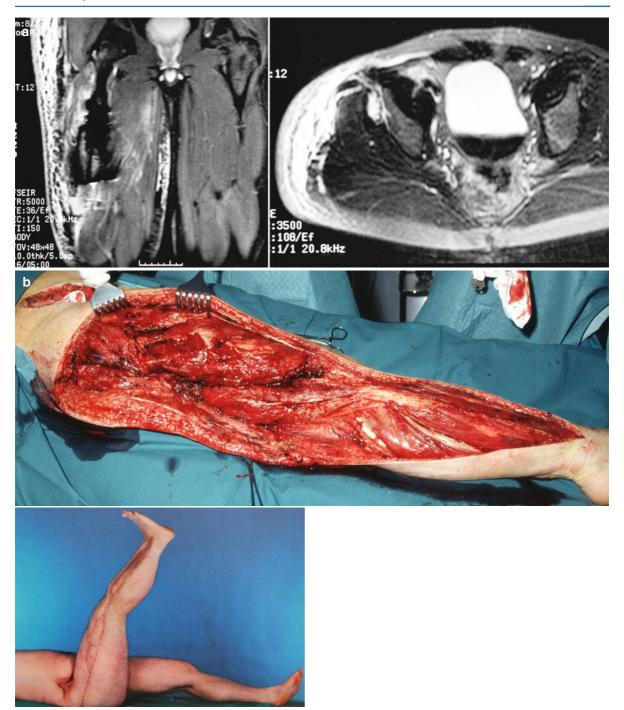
(a) Myonecrosis of right thigh because of *Clostridium perfingens*: MRI at admission. (b) Status after radical débridement including right retroperitoneal space, several "second-look" procedures, and the final result after wound healing and skin grafting
